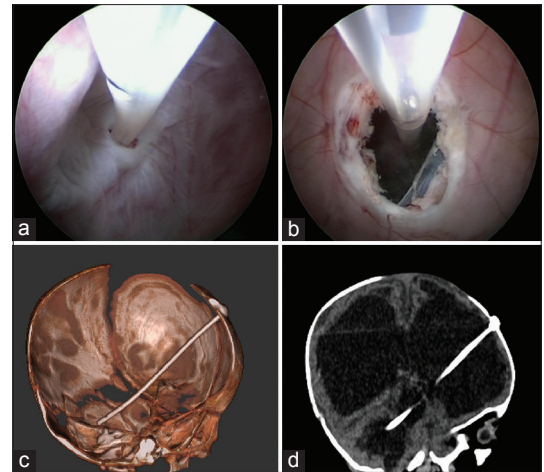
Case 1. Intraoperative photographs. (a) The endoscope is inside of cavity of III ventricle cyst. The rear wall of the cyst separated this chamber from the IV ventricle was perforated and the wall inside the IV ventricle was fenestrated. Into the cavity of the IV ventricle installed silicone catheter. (b) The endoscope was removed from the III ventricle cyst into the right lateral ventricle. A hole in the front wall of the cyst is seen. The catheter follows from the IV ventricle through the III ventricle into the right lateral ventricle. (c and d) The postoperative computed tomography of the brain shows the stent for connecting IV, III, and lateral ventricles
